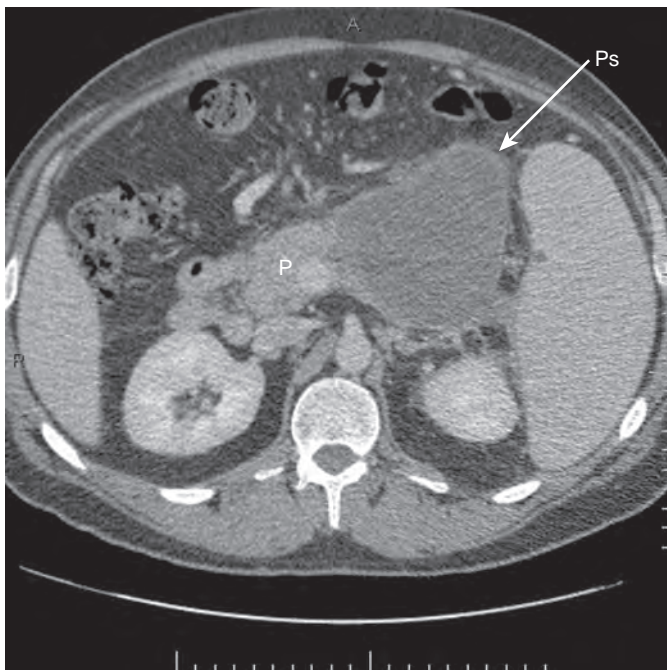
Pseudocyst. Axial CT demonstrating a pseudocyst (Ps, arrow) near the pancreas (P).
